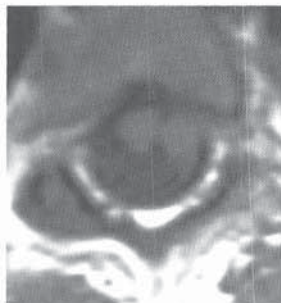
MRI of a patient with diastematomyelia. Note the splitting of the spinal cord (“diastematomyelia”) around the osteocartilaginous spicule.
